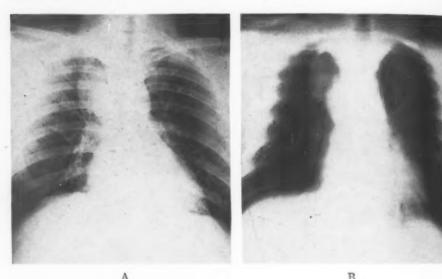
Case 6: A. Roentgenogram shows double bronchiogenic cyst projecting from right upper mediastinum.
